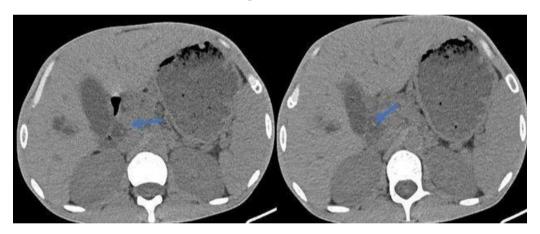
(A, B). Non contrast CT images reveal isodense dot surrounded by hypodense bile in dilated CBD ('Bulls-eye' appearance)
